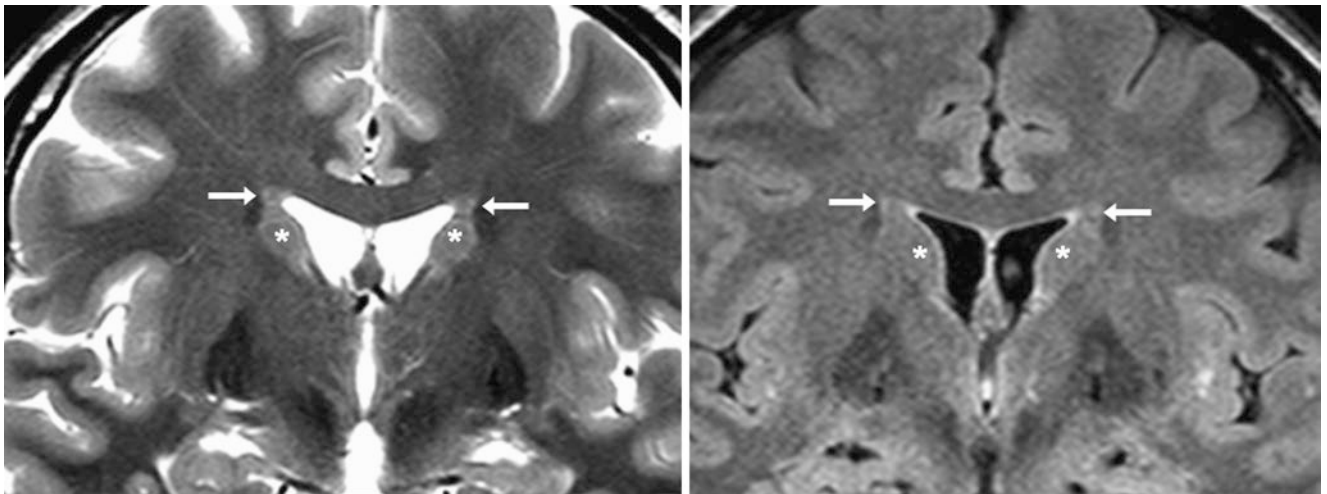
A 27 year old volunteer whose tests showed coronal 3 T MRI T2WI (*left*) and FLAIR (*right*) images, which demonstrate bilateral PEPs (arrows) that have signal intensity similar to the caudate heads (*). This caused the radiologist to initially call the PEPs nodular
